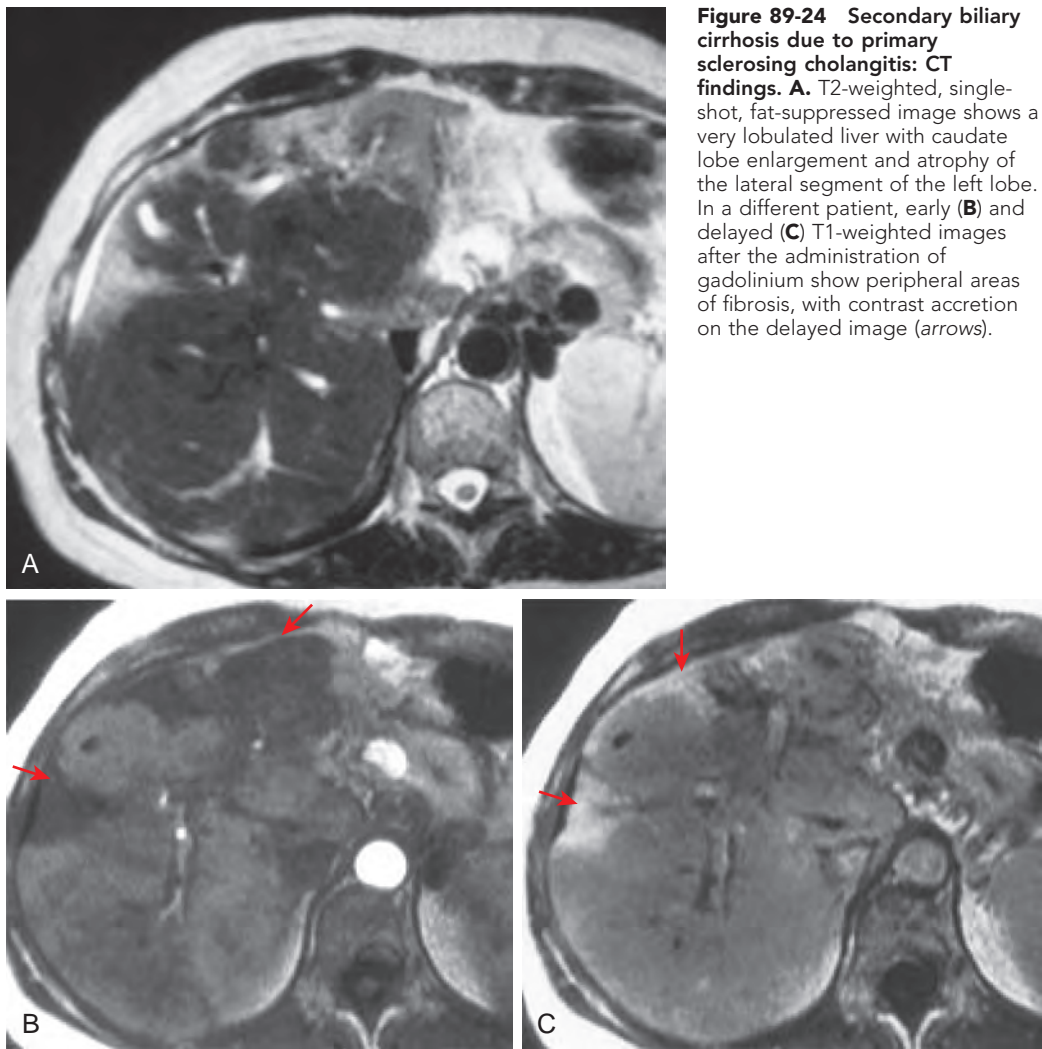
Secondary biliary cirrhosis due to primary sclerosing cholangitis: CT findings. A. T2-weighted, single-shot, fat-suppressed image shows a very lobulated liver with caudate lobe enlargement and atrophy of the lateral segment of the left lobe. In a different patient, early (B) and delayed (C) T1-weighted images after the administration of gadolinium show peripheral areas of fibrosis, with contrast accretion on the delayed image (arrows).
